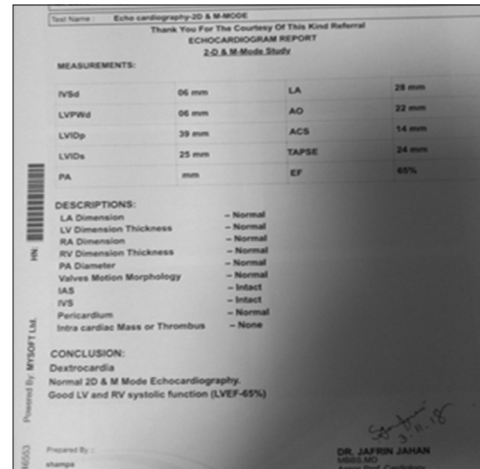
Echocardiogram report
